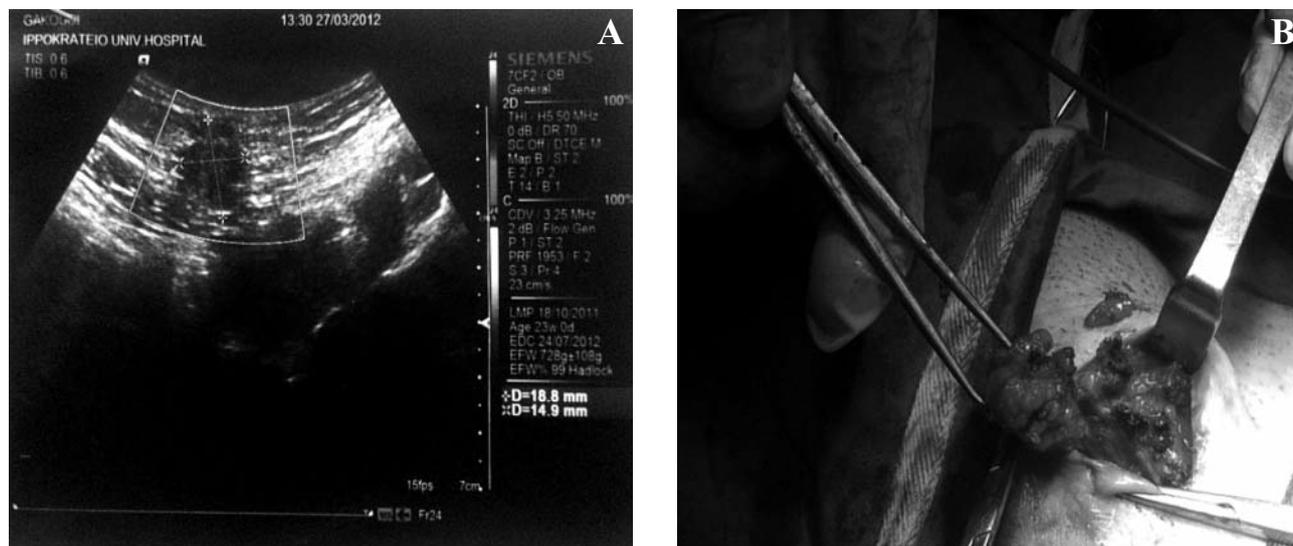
A) Ultrasound image demonstrating a compact, round, hypoechoic subcutaneous mass (18.8 x 14.9 mm). B) Mass (3.5 x 2.4 x 2 cm) of hard texture and irregular shape, firmly attached to the surrounding fatty tissue.
